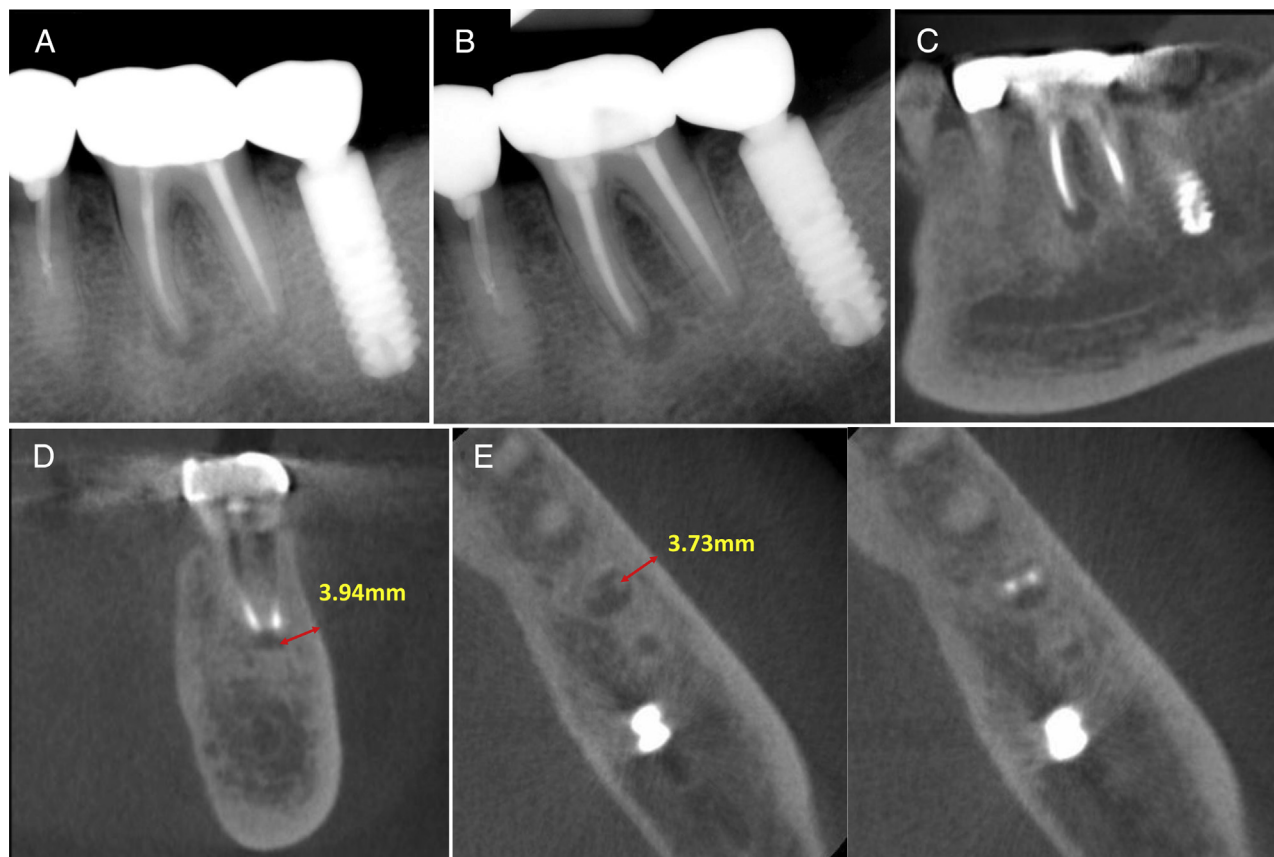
(A) The initial periapical x-ray of tooth 19 exhibiting a periapical lesion. (B) The periapical x-ray 2 years after nonsurgical retreatment. (C) A reformatted panoramic view of the CBCT scan revealing a periapical lesion in the mesial root of tooth 19. (D) A coronal view of the CBCT scan. A thick and intact buccal cortical bone was detected on (E) the axial view of the CBCT scan.
